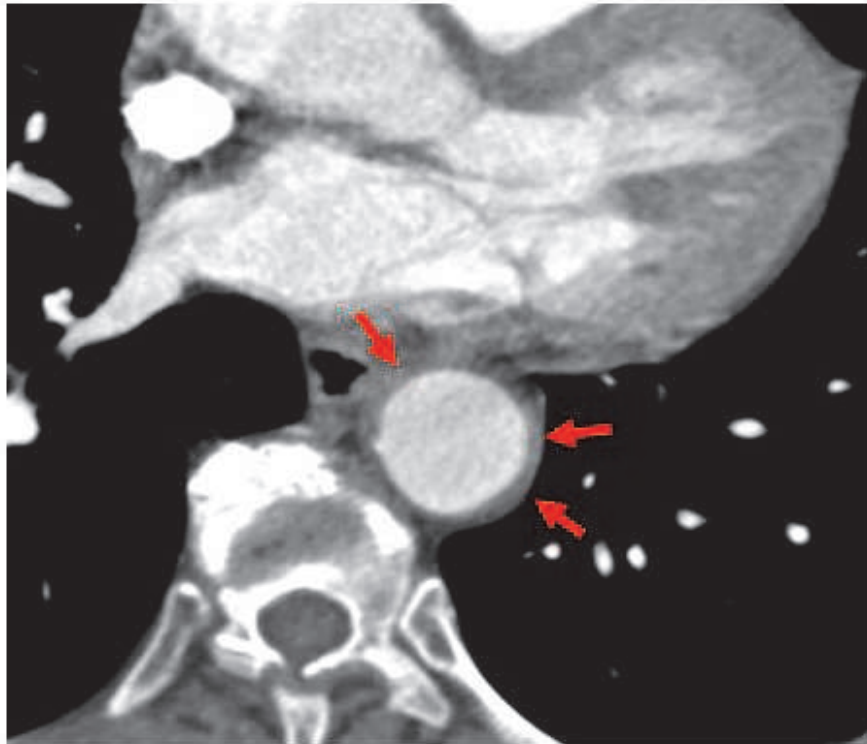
Cross-sectional view of a CT angiography of a patient with newly diagnosed GCA displaying a marked circumferential thickening of the aortic wall.
